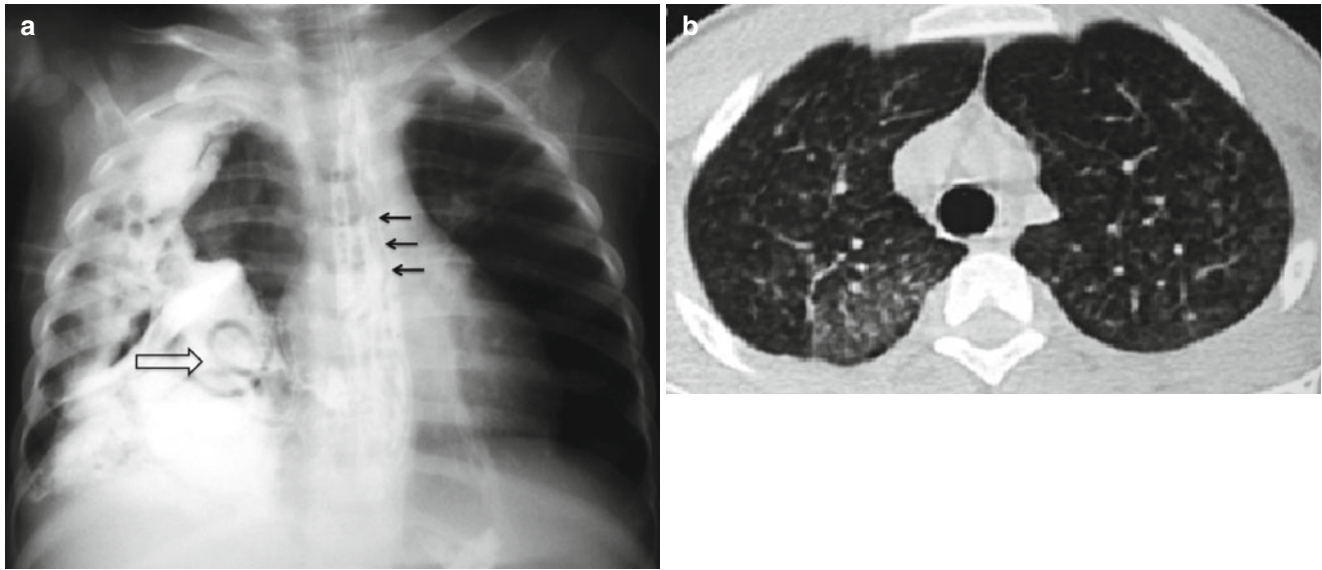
Ascariasis. Chest radiograph following barium study (a) demonstrates *Ascaris* within the esophagus (*small black arrows*) as well as in the right pleural cavity (*open arrow*) indicative of esophageal
